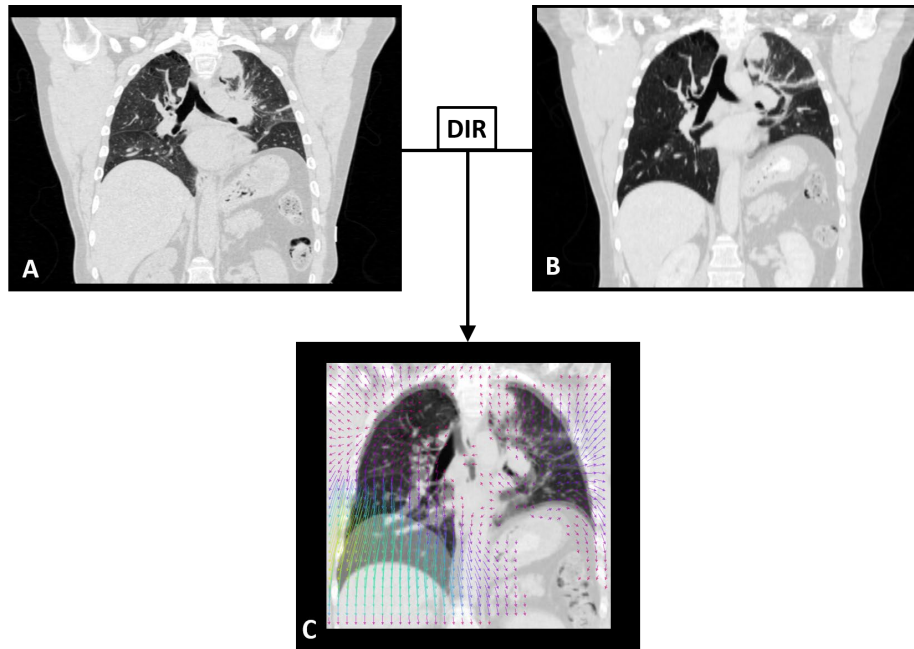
Example of intensity-based DIR for a lung patient with CT images acquired in different breathing states. Image A shows a deep exhale CT, Image B shows a breath-hold treatment planning CT, and Image C shows an overlay of the images with the DIR calculated DVF.
